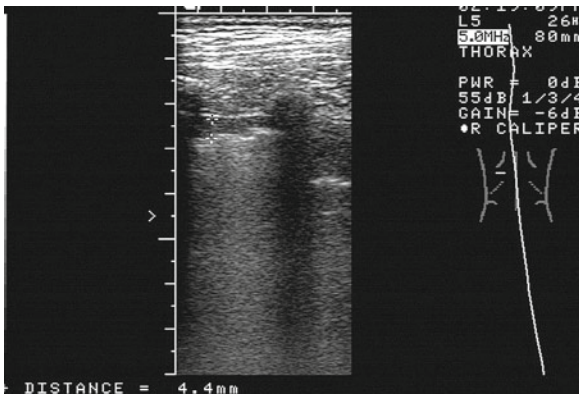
A 44-year-old man with fever and pain in the right side of the chest in basal location. Sonography reveals fox-earthlike spread of abscesses in the soft tissue of the chest wall. The aspirated substance shows evidence of actinomyces
